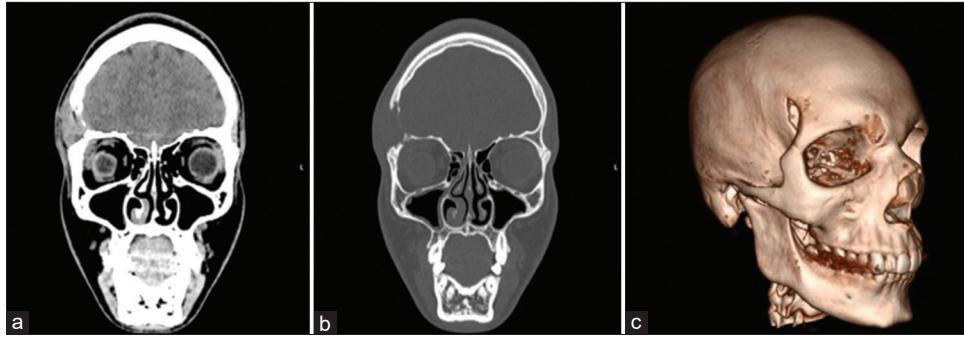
(a) Coronal plane of the preoperative, non-enhanced CT scan of the head, soft tissue window, (b) bone window, and (c) Volume rendering technique (VRT) revealed a defect of the right-sided frontal bone.
